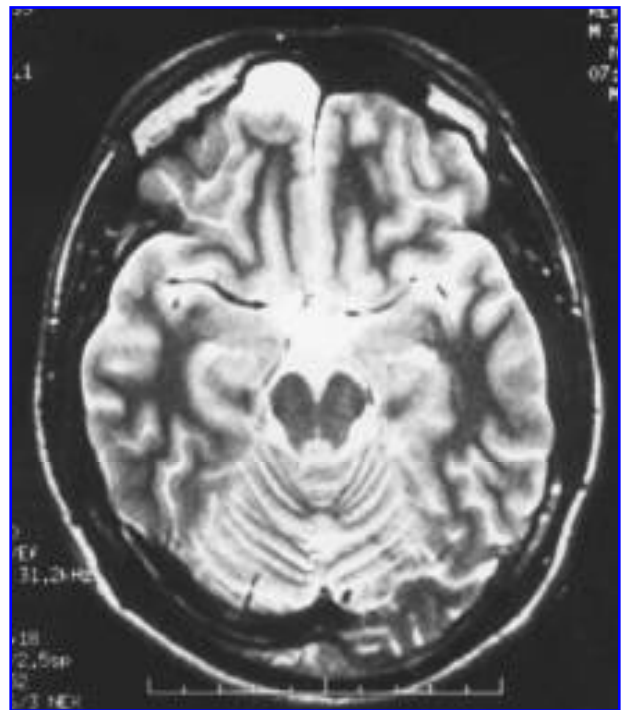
Axial T2-weighted image demonstrating the subarachnoid cyst in the left frontal area. Spinal fluid in the cyst is white.
